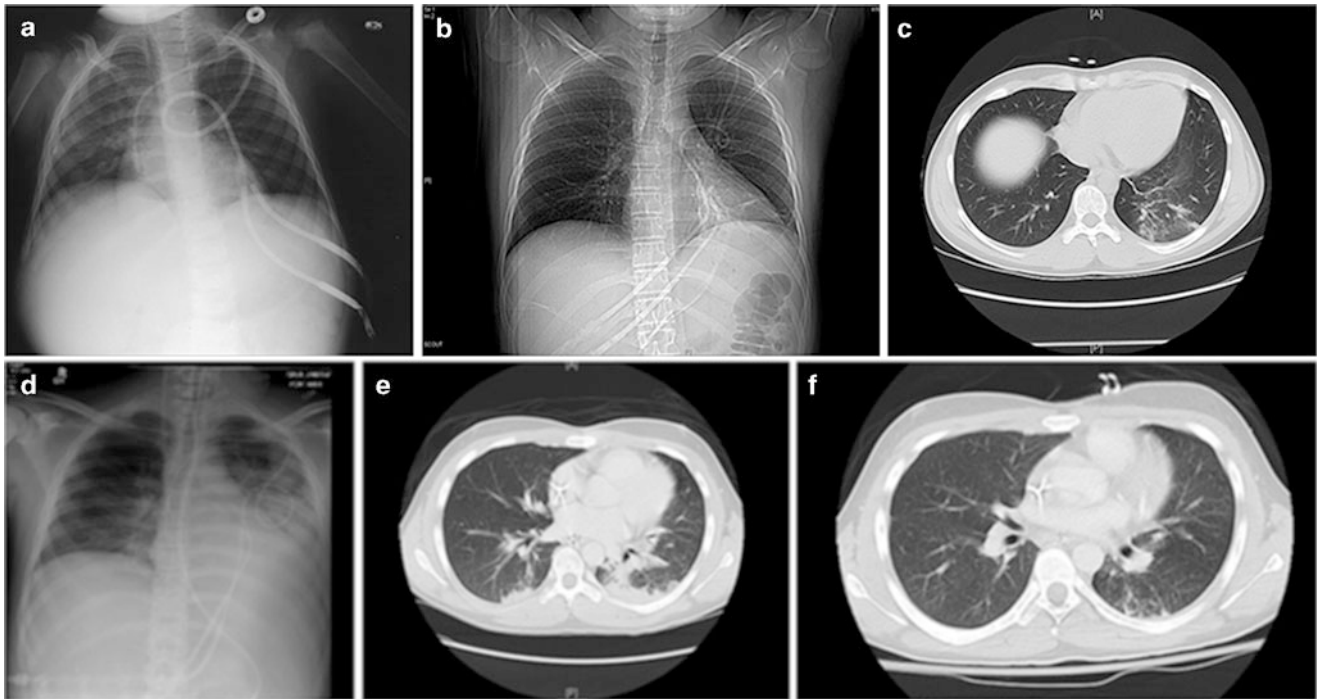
Chest radiographs of transplant recipients with RSV and hMPV lower respiratory tract disease. (a) Three-year-old with RSV pneumonia developing 1 week post HSCT, which proved to be fatal within 2 weeks despite antiviral therapy with aerosolized ribavirin. (b) HMPV Lower respiratory tract disease in a 16-year-old boy with ALL and hMPV disease diagnosed day 5 after a matched related BMT. He was diagnosed with hMPV infection on day #5 posttransplant, with clinical findings of mild respiratory distress with cough and abnormal chest radiograph showing interstitial infiltrates. Aerosolized ribavirin and IVIG therapy was initiated. (c) Posttransplant day #9: He required intubation due to respiratory failure and acute respiratory distress syndrome, with left sided pneumonia and increasing pleural effusion. He required mechanical ventilation and 50% FiO₂. (d) Post Tx day #11: Worsening of left lower basilar consolidation with small left pleural effusion, but oxygen requirement down to 35% FiO₂; not yet engrafted and continued on ribavirin. (e) Day #16: Now engrafted and ribavirin discontinued. He was able to be extubated and relatively quickly weaned to room air. (f) Patient with improvement post engraftment on day #16 posttransplant. Chest CT shows interval improvement in bilateral patchy groundglass opacities and in left lower lobe consolidation. He received supportive care and 10 days of aerosolized ribavirin therapy, which did not substantially impact viral load, but he improved clinically concomitant with engraftment. He was subsequently extubated and discharged several weeks later.
